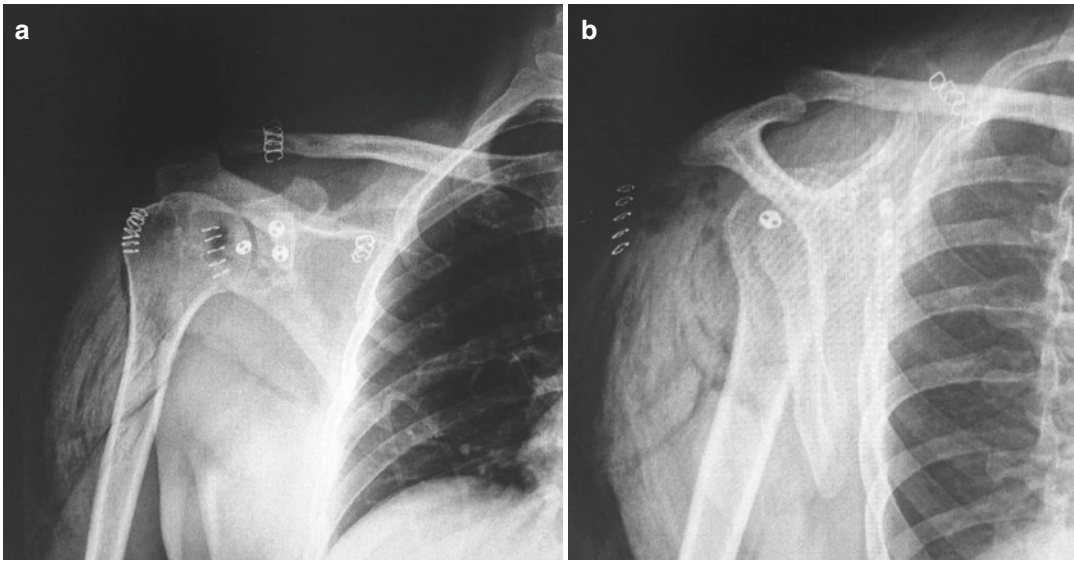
Postoperative radiographs of a glenoid augmentation technique for instability using iliac crest bone graft fixed with a double suture-button technique. Anteroposterior (a) and lateral (b) views
